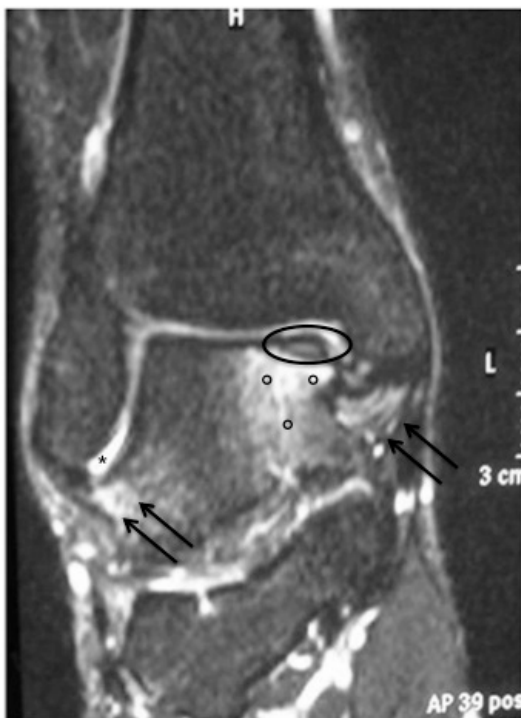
(Seite 9). MRI bei osteochondraler Läsion des Talus. Folgende Gewebe sind mitbeteiligt: Knorpel mit einem Knorpelfragment und Unterbrechung der Grenzlamelle (Kreis), Knochen mit subchondralem Bone Bruise (°), Synovia mit Erguss und Synovitis (*), Ligamente mit Insuffizienz und Avulsionsverletzung (Pfeile). Abbildung aus Leumann et al. (2011a).
